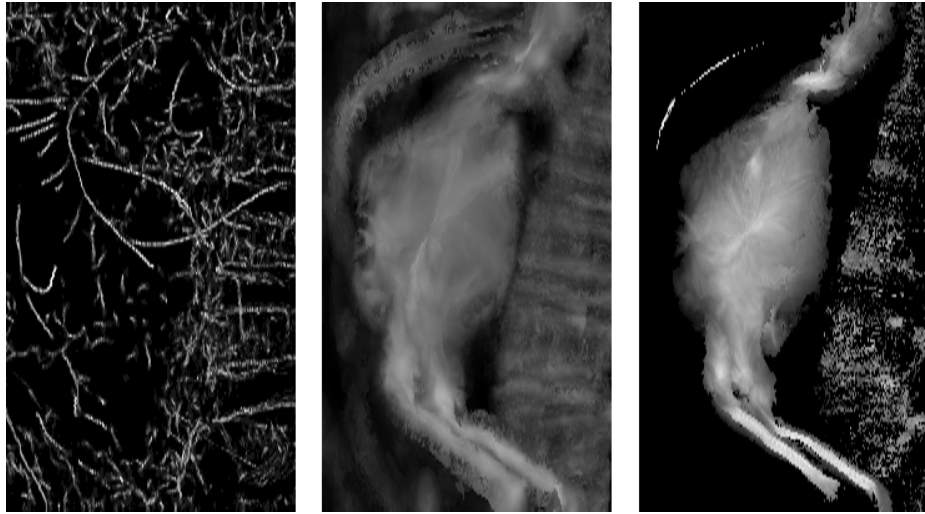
Maximum intensity projection of TDF responses on a CT image of an abdominal aortic aneurysm (AAA) using the same GVF vector field. Left: Vesselness TDF. Middle: Circle fitting TDF. Right: Proposed TDF. The same level and window were used on the circle fitting and proposed TDF. A different level and window were used for the vesselness TDF as its range is exponential.
